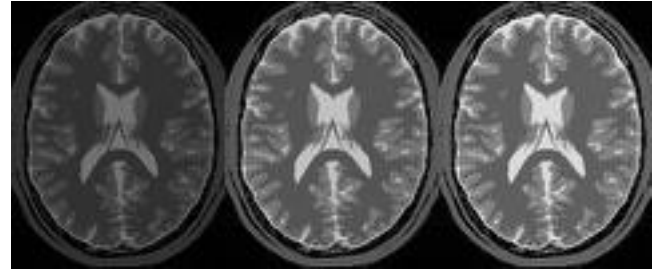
MR images on increasing flip angle (left to right)
